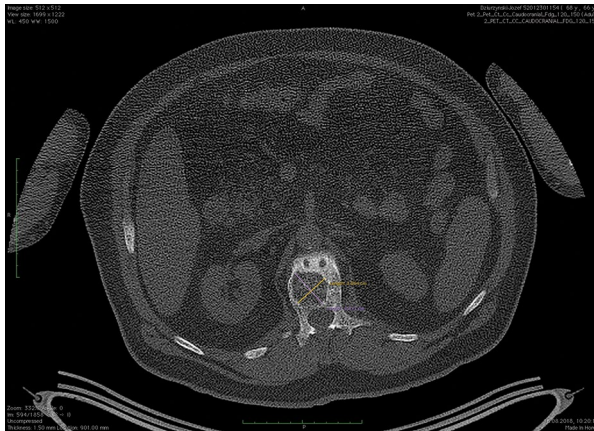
Osteolytic focus in the L1 vertebral body on computed tomography scan (patient 1)
